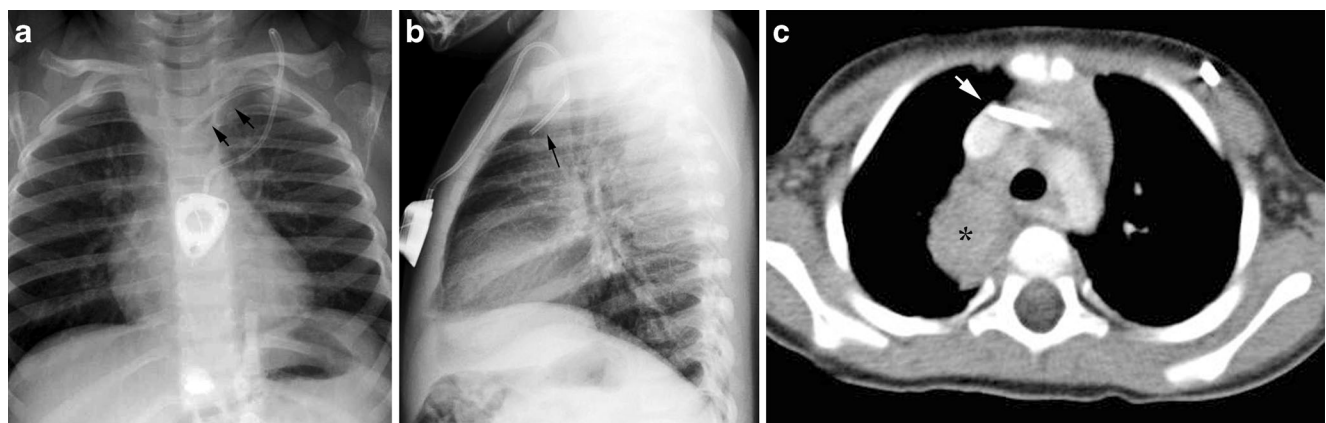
Venous catheter position mimicking arterial placement in a 17-month-old girl with neuroblastoma. a Anteroposterior chest radiograph shows an oblique course of the venous catheter (*arrows*), inserted via a left subclavian approach. b Lateral chest radiograph shows exaggerated
